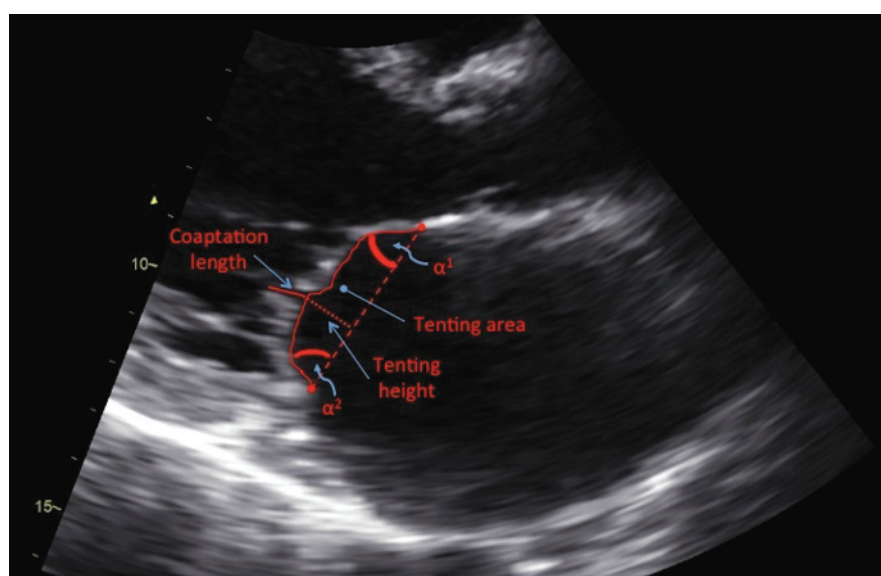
Parasternal long-axis view of the mitral valve in mid-systole on transthoracic echocardiogram. α_1 , anterior leaflet tethering angle; α_2 , posterior leaflet tethering angle; tenting area, area enclosed by the mitral leaflets and annular plane.
